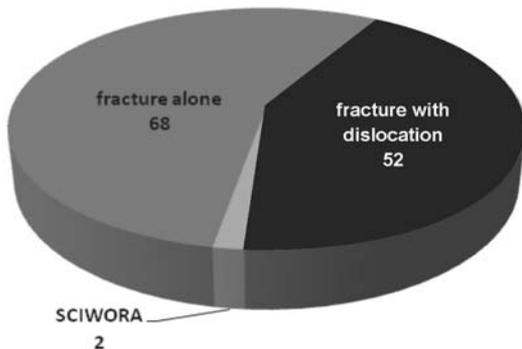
Patterns of injury as evident on CT radiography
